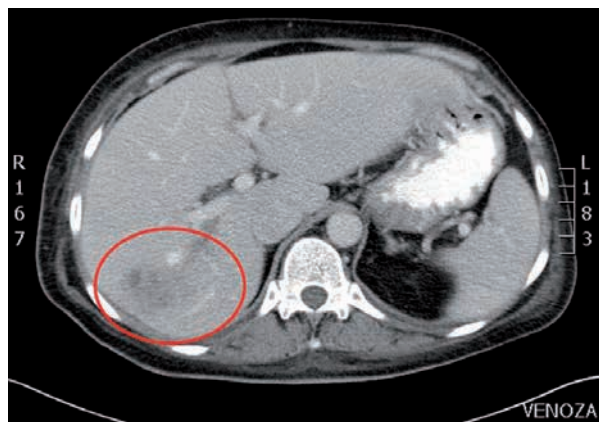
Contrast-enhanced abdominal computed tomography findings in the venous phase. Note the hypodense liver mass (encircled).
